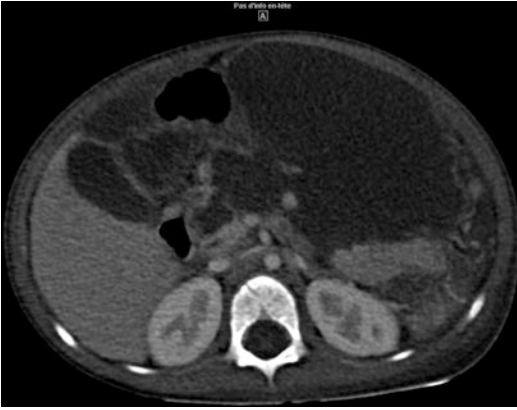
Same patient than Fig. 16.11. CE-CT performed 4 weeks later at the same level than Fig. 16.11 shows destruction of the head and body of the pancreas and large well-limited pseudocyst which was drained endoscopically
